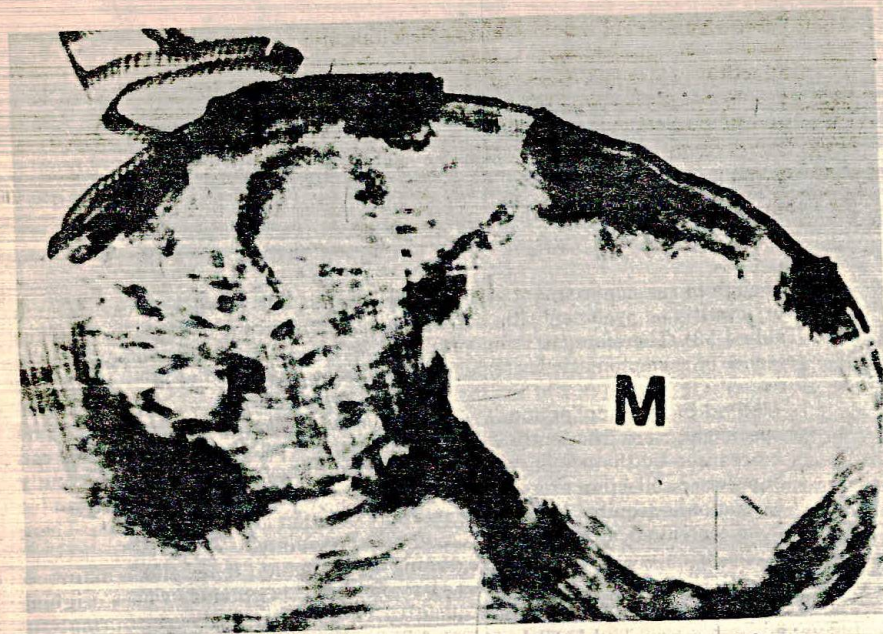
Transverse sonogram. The large echo-free mass (M) on the right corresponded to an enlarged, fluid containing mass, which was first discovered and subsequently became infected during pregnancy. The uterus is on the left, the placenta (P) is posterior. (From M. D. Lindheimer, A. I. Katz, *Kidney Function and Disease in Pregnancy*. New York: Lea & Febiger, 1977. Courtesy of J. D. Bowie, M.D.)
